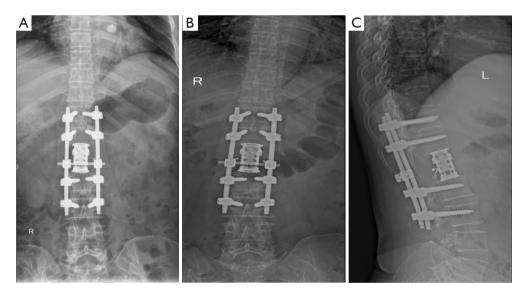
Postoperative and 9-month follow-up X-rays. (A) Postoperative anteroposterior X-rays, and anteroposterior (B) and lateral (C) X-rays after 9-month follow-up. R, right; L, left.
